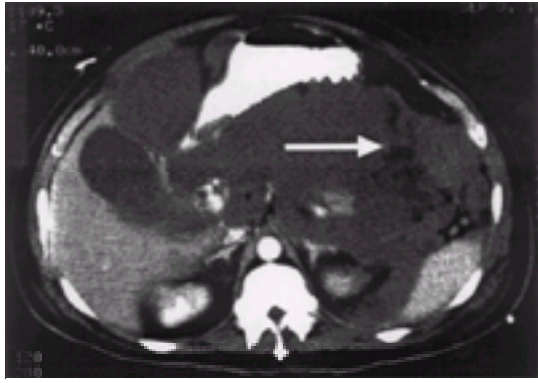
Helical CT scan revealing gas bubbles in the pancreatic phlegmon.
